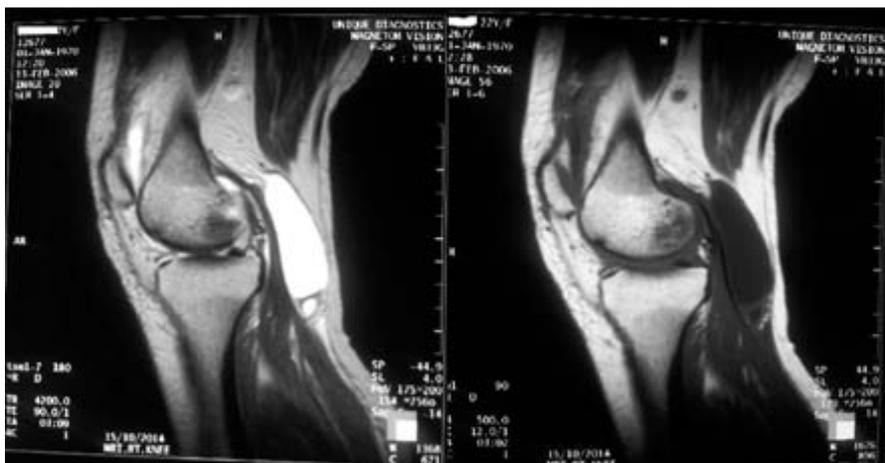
(a and b) T1 and T2 weighted sagittal MR images revealed tear in the posterior horn of medial meniscus along with a well-defined, cystic lesion in gastrocnemius–semimembranosus bursa appearing hypointense in T1 and hyperintense on T2 weighted images suggestive of a Baker's cyst.
